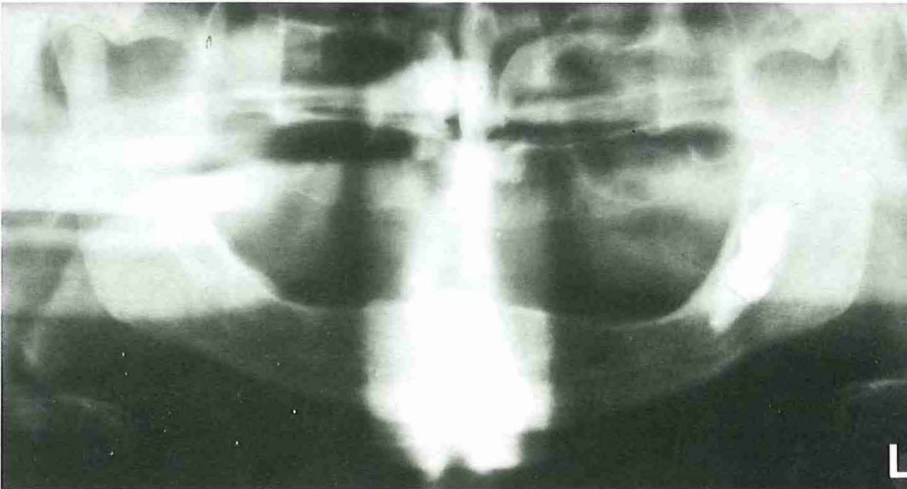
Orthopantomogram of a 54-year-old male showing distal horizontal impaction of the second molar and mesial horizontal impaction of the third molar in the mandible on the left side.
